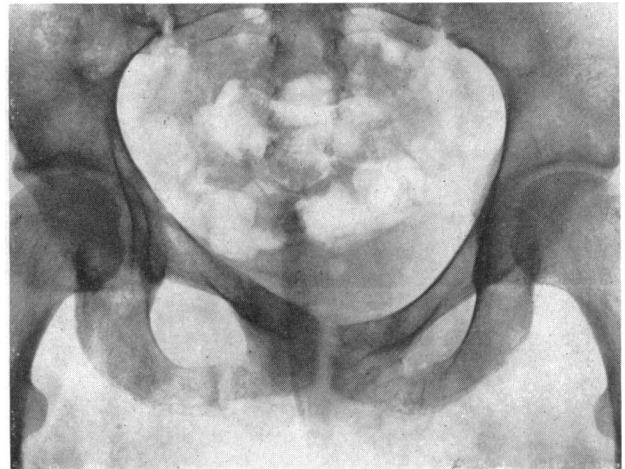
Radiograph of pelvis on December 20, 1954, showing Looser's zones of both ischial rami.
